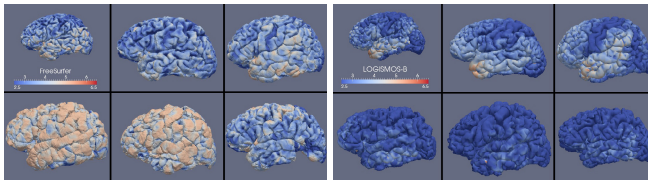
FS and LOGISMOS-B CT(JHU). Top row, healthy, bottom, MS patients.
